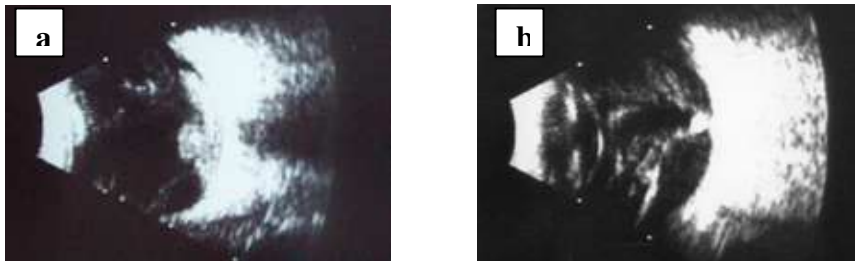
Ultrasonographic image 70 dB, C12 a: posterior pole pre-retinal hemorrhage and vitreous hemorrhage 1st day after paintball injury, VA LP; b: 3 weeks after paintball injury, VA LP
